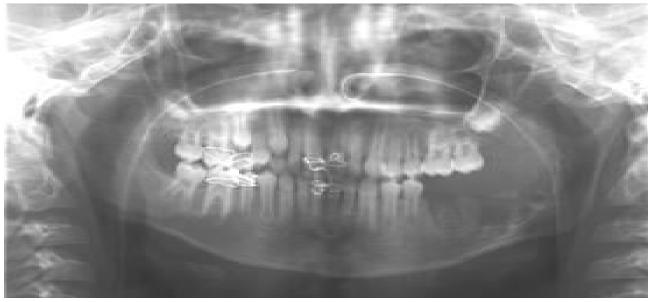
Post operative panoramic radiograph showing extracted tooth no 36 and 37 with area of resection.
